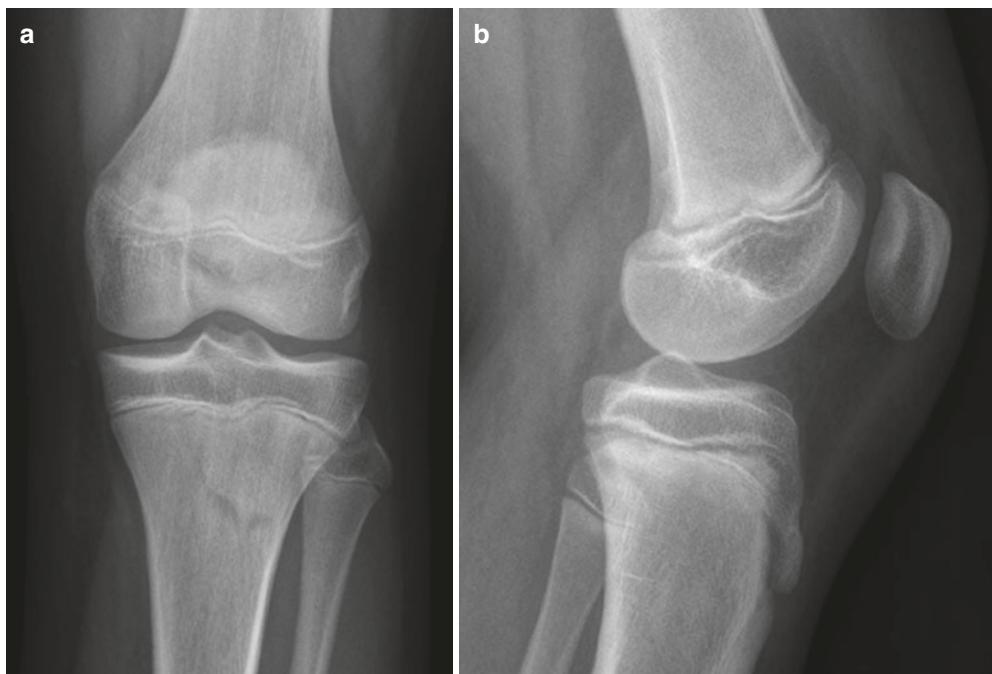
(a) Frontal radiograph of the knee, showing an apparent fracture line in the tibial metaphysis. (b) Lateral view confirming that this represents the physis of a normal tibial tubercle
